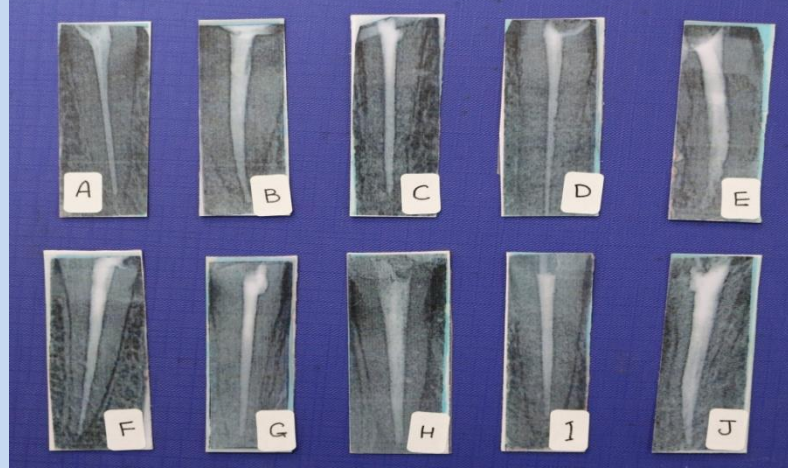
Radiographs represent post-mortem labelled from (A-J)
